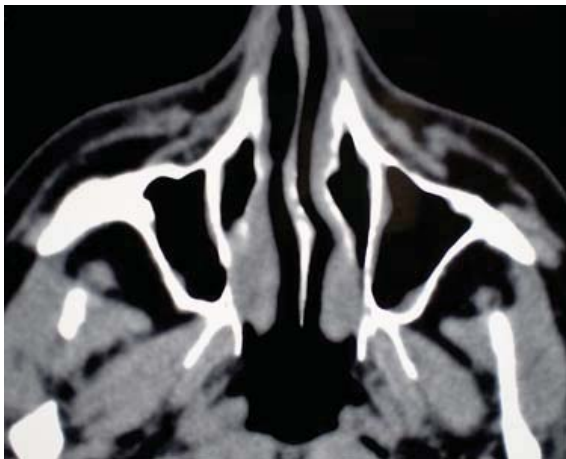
Computed tomography of paranasal sinuses (axial view) a year after the treatment, shows the normal anatomy
